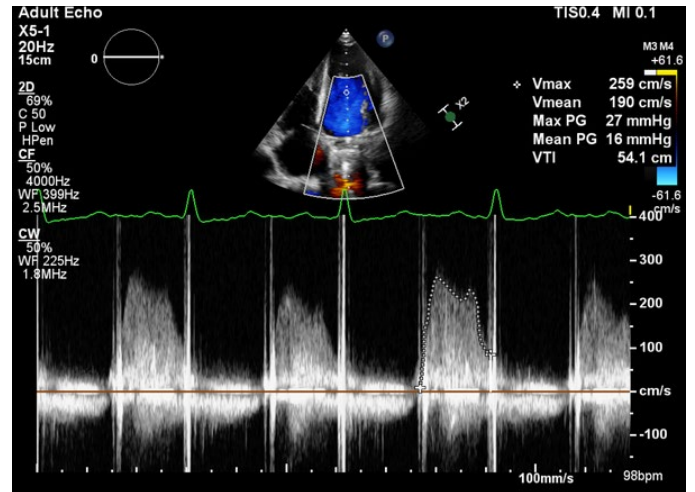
Transthoracic echocardiography: CW-Doppler of transmitral inflow revealing severe functional mechanical mitral valve stenosis (dpmean 16mmHg; HR 98bpm; Hemoglobin 63g/l)
